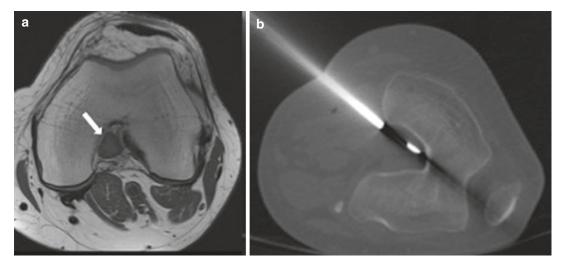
Soft tissue mass in a 45-year-old man. (a) Axial proton density image. (b) Computed tomography (CT). MR shows the soft tissue synovial mass (*arrow*), which was biopsied under CT guidance
